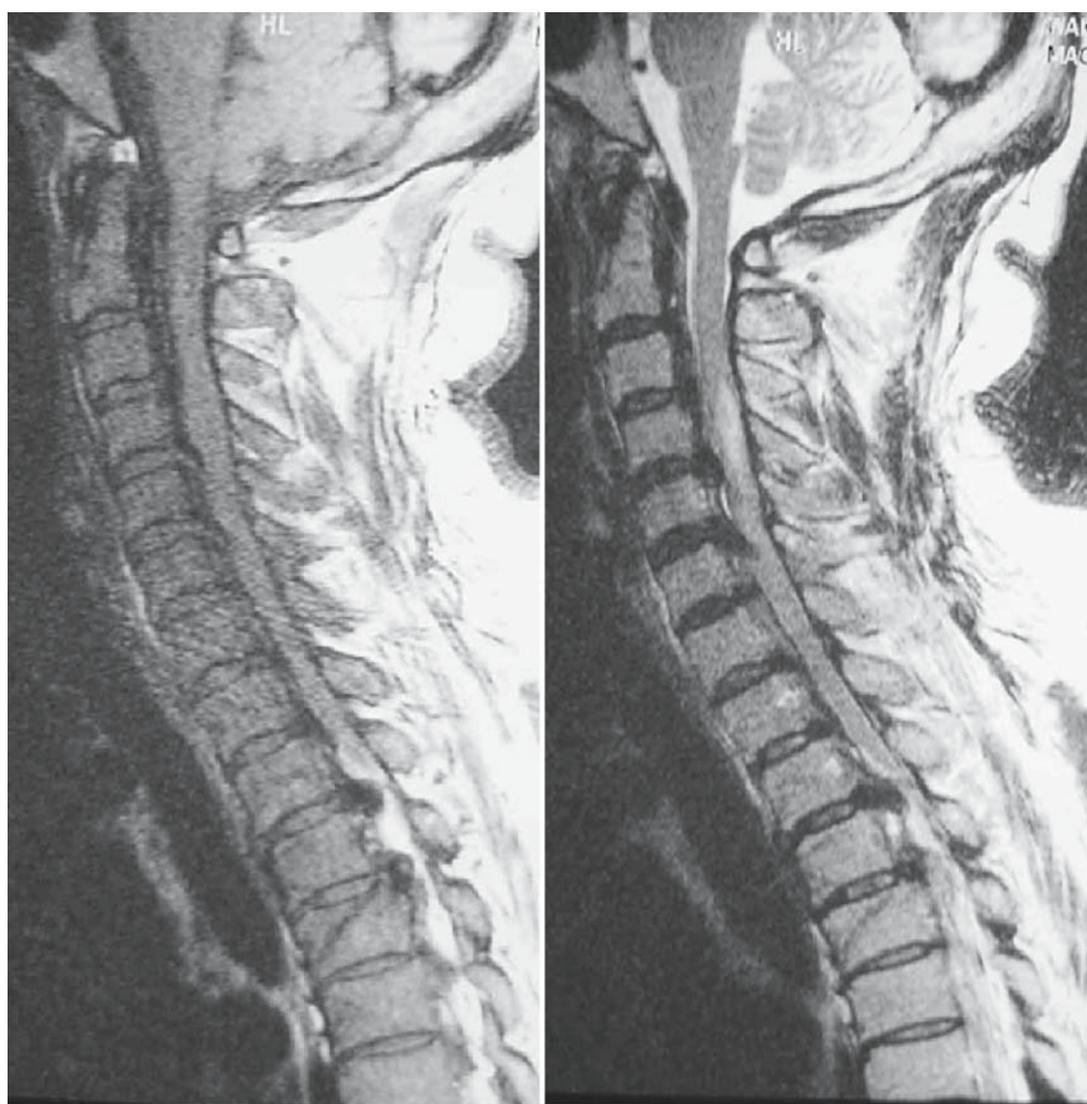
Magnetic resonance imaging (MRI) before (a) and after (b) performing posterior extensive cervicothoracic laminoplasty (PECTL). Spinal cord was decompressed by posterior shift of the spinal cord (b)
